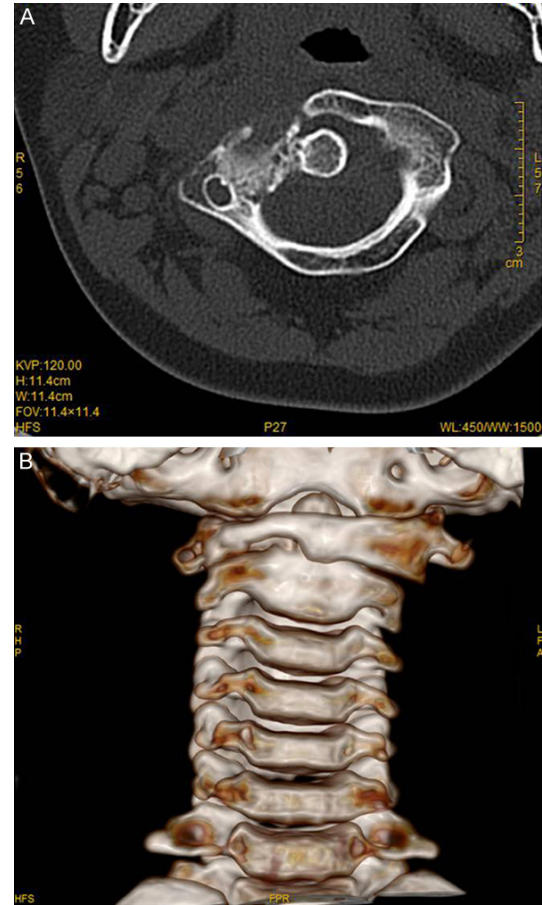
A. Axial cervical spine enhanced CT film 3 months postoperatively, showing atlantoaxial vertebral bone with artificial implantation and no necrosis. Artificially implanted tissue had partly fused with the bone bed with no evidence of lesion recurrence. B. Cervical spine 3D reconstruction 3 month postoperatively, showing partially repaired atlanto-axial vertebral body.
